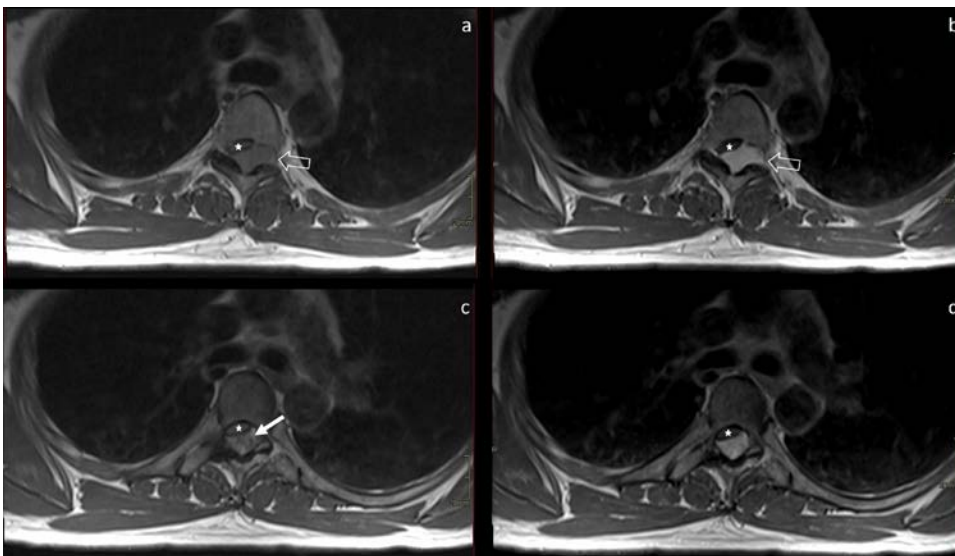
Axial T1-weighted pre-contrast (a, c) and corresponding T1-weighted post-contrast (b, d) images at the level of the T4-T5 intervertebral foramen and the T5 vertebral body.
